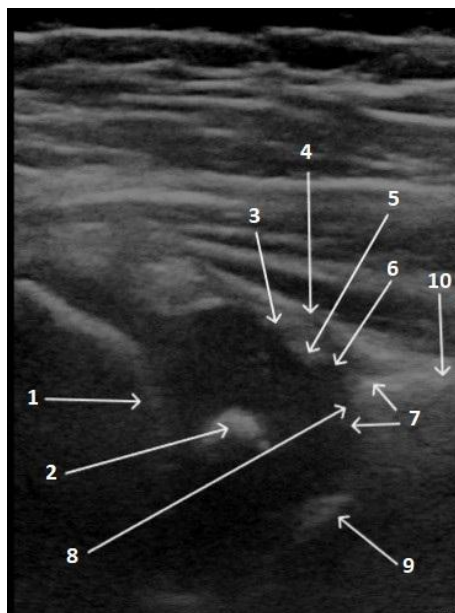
Anatomic structures in the standard plane of hip ultrasound according to Graf: 1-chondro-osseous border, 2-femoral head (with ossific nucleus in this case), 3-synovial fold, 4-joint capsule, 5-labrum, 6-cartilaginous roof, 7-bony roof, 8-bony rim, 9-iliac wing, 10-lower limb of os ilium
